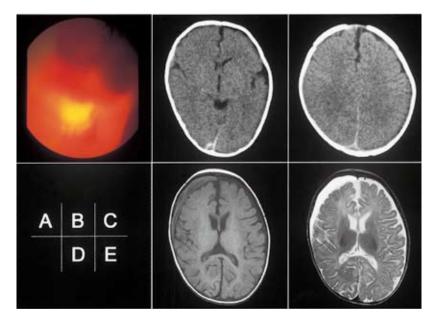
A: In the fundus examination performed on fourth day from admission, diffuse preretinal bleeding with soft exudates was observed. B, C: Brain CT showed images of subdural hemorrhage along the cerebral falx and cerebral edema. D, E: In the T1-weighted image (D) and T2-weighted image (E) of the brain MRI performed at 3 months after onset, the subdural hematoma remained in the right anterior temporal area.
